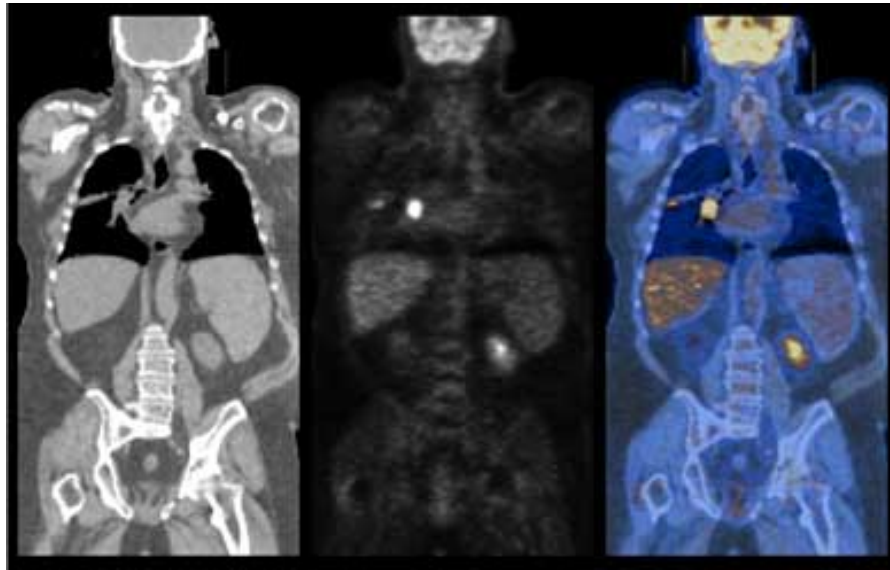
Comparison between CT (left), MRI (middle) and PET (right).
